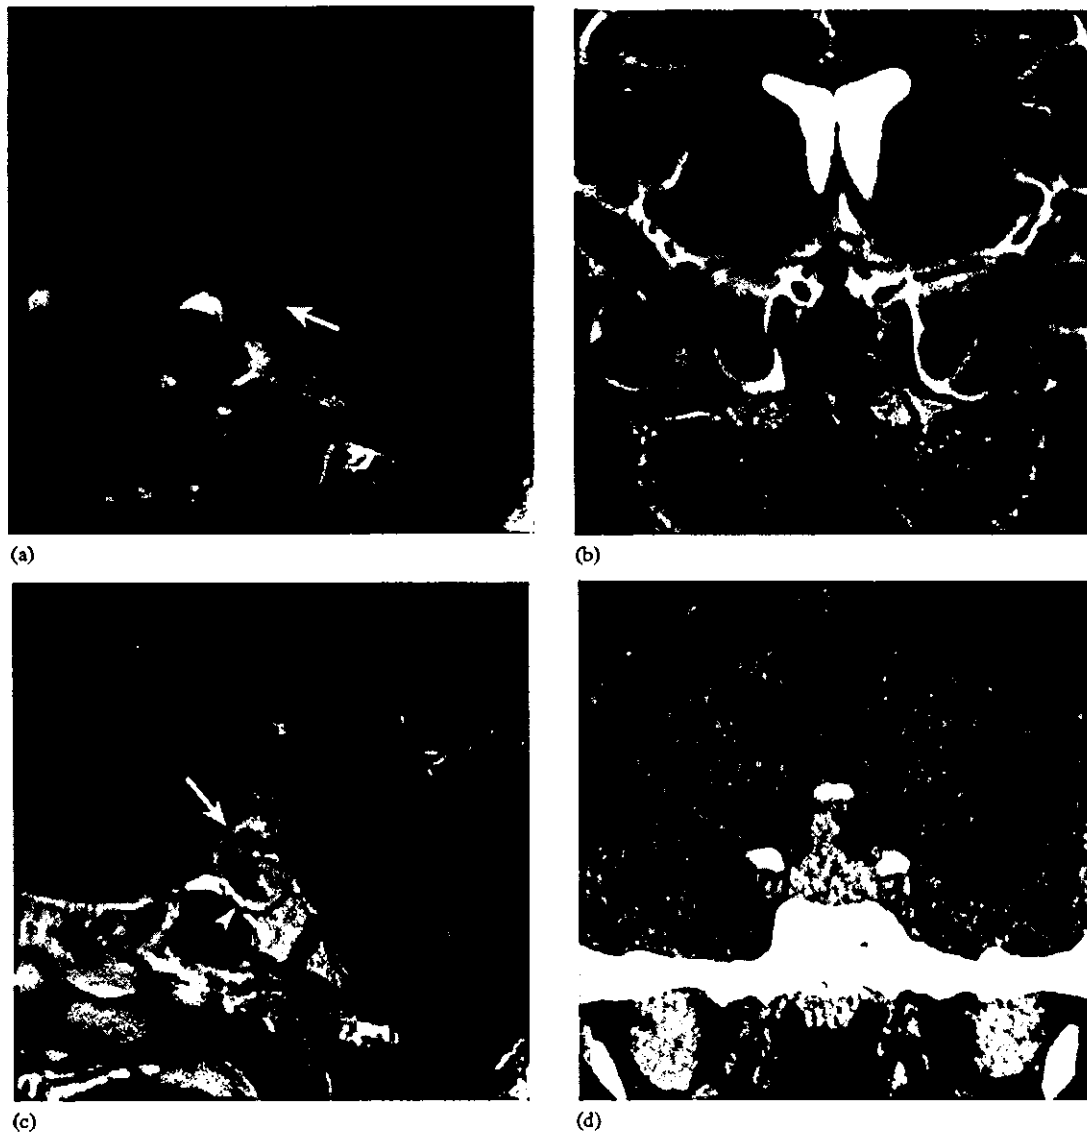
Case 8. Neurohypophyseal germinoma in an 11-year-old girl. Intra- and suprasellar tumor components are homogeneous and isointense to cerebral cortex on both T1-weighted (SE 400/15) (a) and T2-weighted (FSE 5000/130) MR images (b). Sagittal T1-weighted MR image (SE 400/15) (a) shows absence of normal signal hyperintensity in the posterior pituitary (arrow). Sagittal post-gadolinium T1-weighted MR image (SE 400/15) (c) shows heterogeneously enhancing tumor involving the intrasellar region and infundibulum. Thickened infundibulum is observed (arrow). The anterior pituitary is compressed anteroinferiorly (arrowhead) [10,18,25]. The tumor is less enhancing than the anterior pituitary. Unenhanced CT reveals a hyperdense tumor with no calcification (d).
